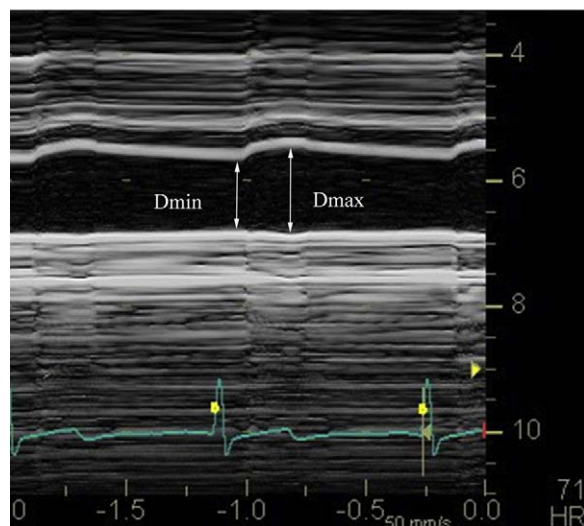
Measurement method of aortic stiffness parameter β_1 by M-mode ultrasonography. D_{\max} , maximal aortic diameter; D_{\min} , minimal aortic diameter.
